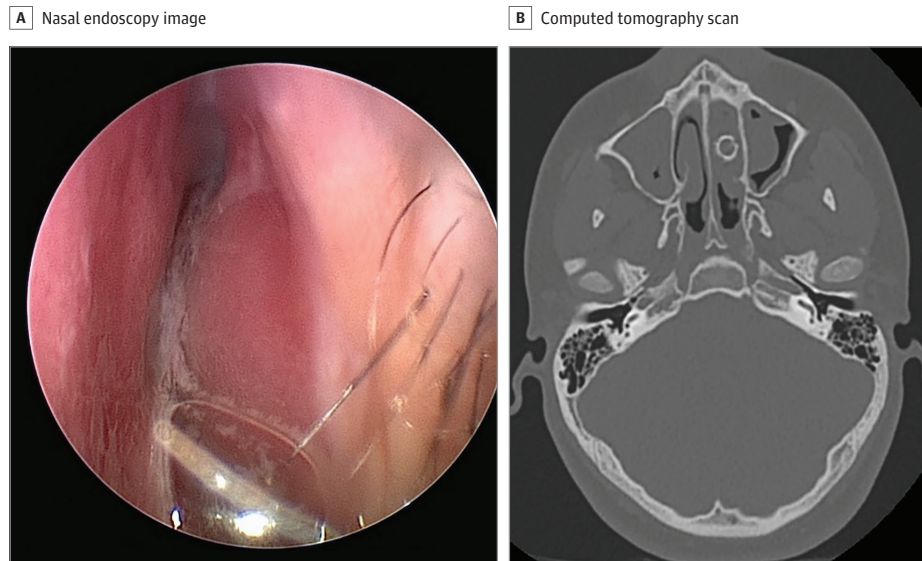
A, Nasal endoscopy showing bilateral and symmetric inferior turbinate hypertrophy without erythema, exudate, or ulceration; without mucoid rhinorrhea; and no intranasal masses, lesions, or polyps. B, Computed tomography of the sinuses showing a 9-mm spherical structure in the left inferior nasal cavity with surrounding spiculated calcifications and chronic dystrophic calcification.
